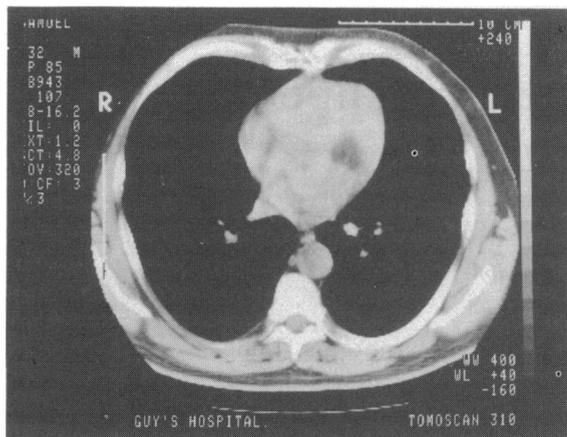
Figure Computed tomogram with contrast enhancement showing a filling defect (dark area) in the cavity of the left ventricle.
